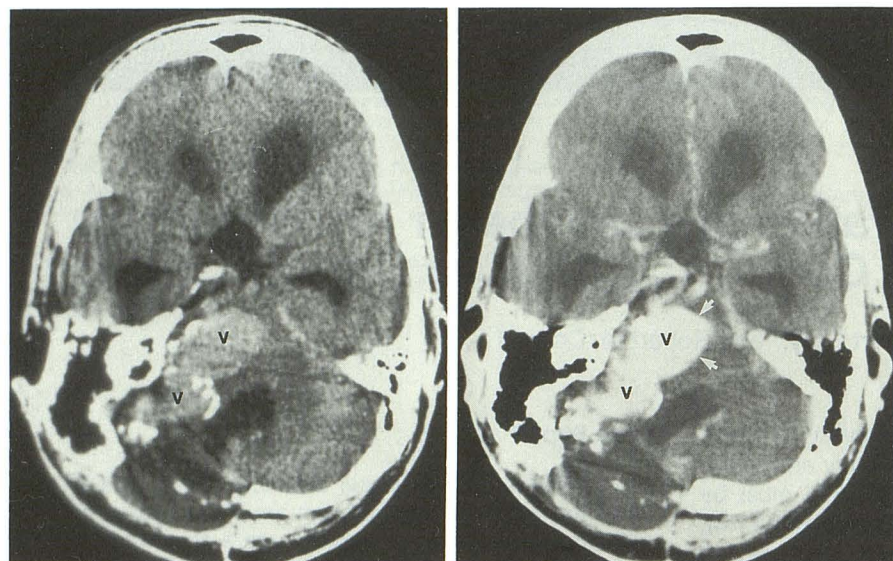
A and B, Axial pre- (A) and postinfusion (B) CT scans obtained before embolization show large, peripherally calcified, enhancing vascular masses (v) in right posterior fossa, representing aneurysmally dilated venous sacs draining the arteriovenous fistula. Brainstem is markedly compressed by the most anteromedial sac (arrows, B). Also note obstructive hydrocephalus and old postoperative changes (suboccipital craniectomy).
